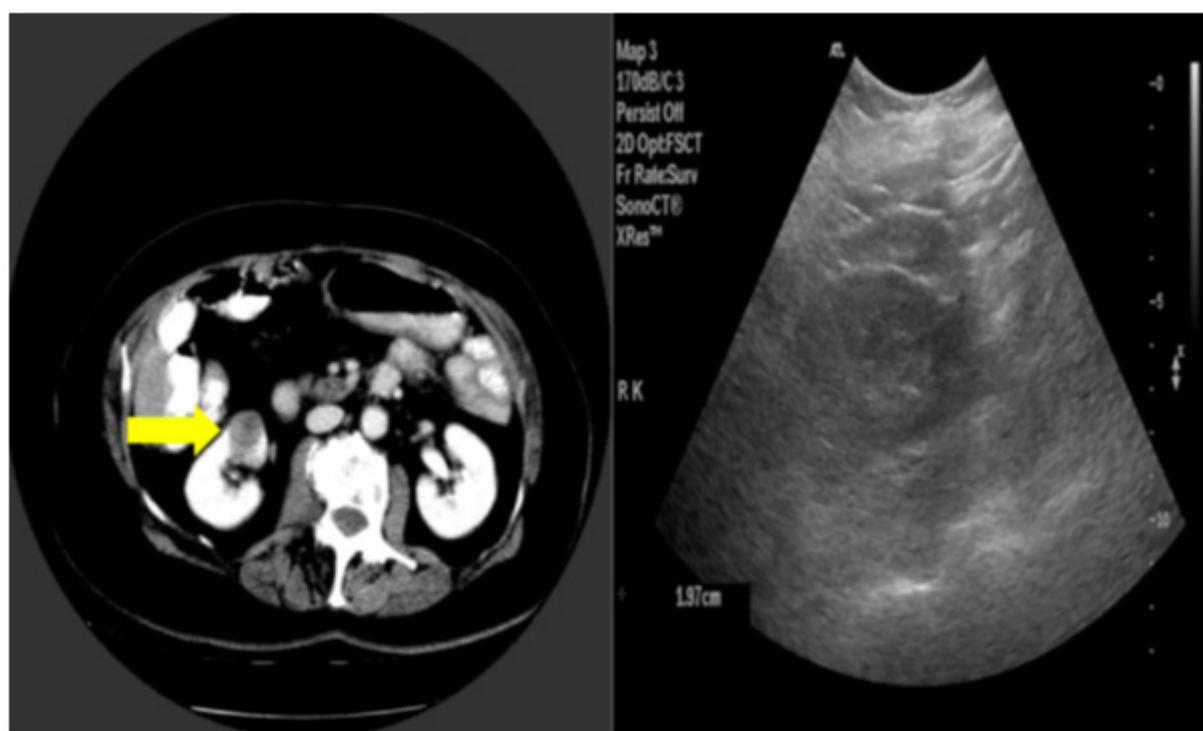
Re-staging CT scan post-operatively and pre-chemotherapy showing renal cyst 1.7cm (left) and renal ultrasound showing 1.9cm renal lesion (right) two months following Image 1.
